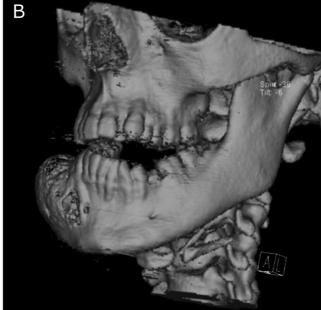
A and B Initial 3D CT reconstruction showing the JAOF of the right body of mandible with moderate lingual expansion.
